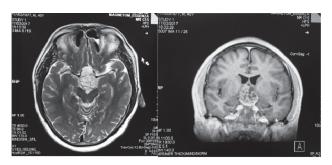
Preoperative MRI scan showing suprasellar lesion, suggestive of craniopharyngioma.
